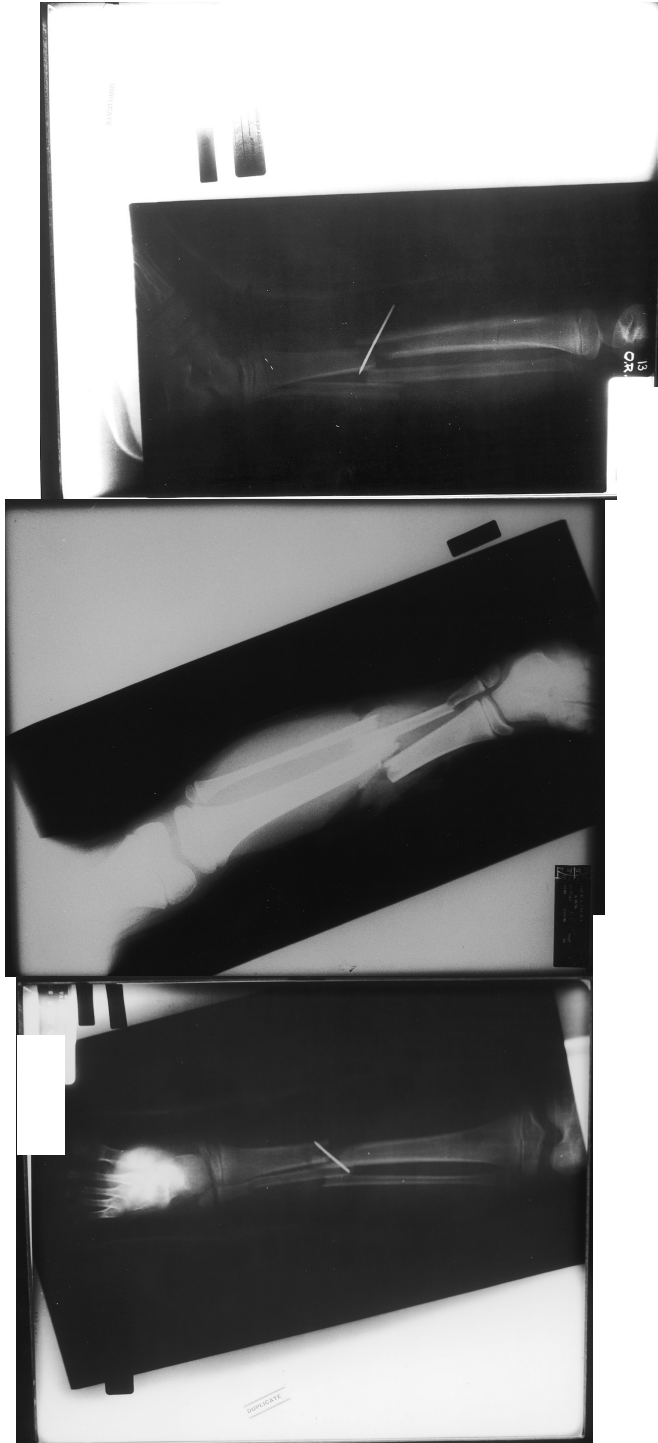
Radiographs from PWC File 2.
